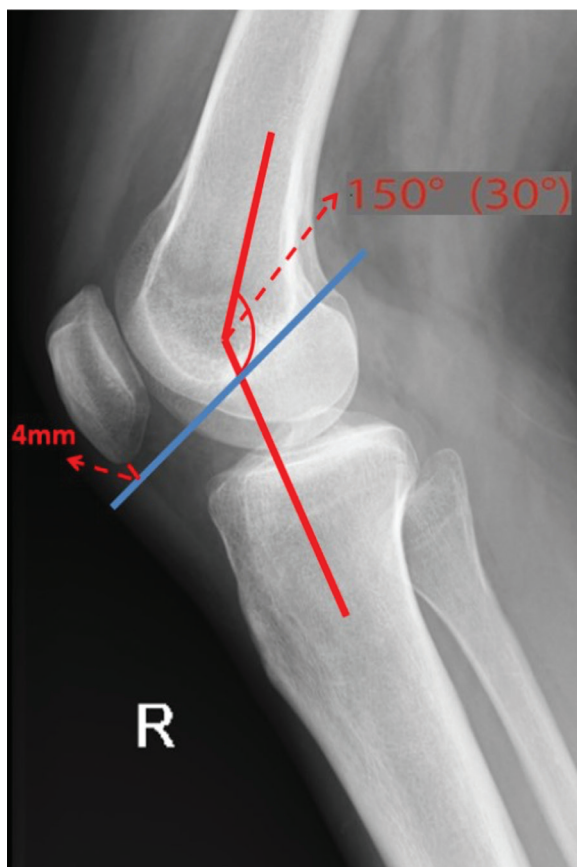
Digital measurement on the direct X-rays using the digital image archiving system
